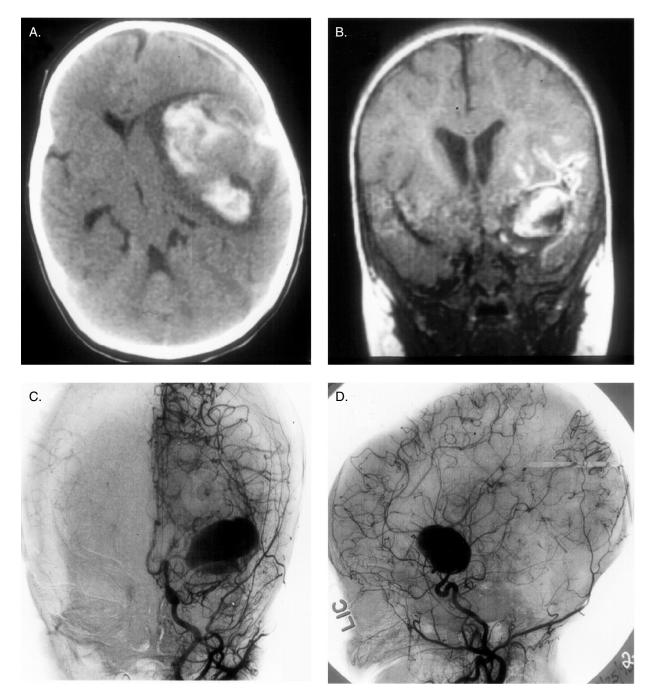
A,* Computed tomographic scan and *B,* magnetic resonance image of an acute left intraparenchymal hemorrhage with mass effect and midline shift. A cerebral angiogram (*C* and *D*) subsequently confirmed the presence of a giant left middle cerebral artery fusiform aneurysm.
